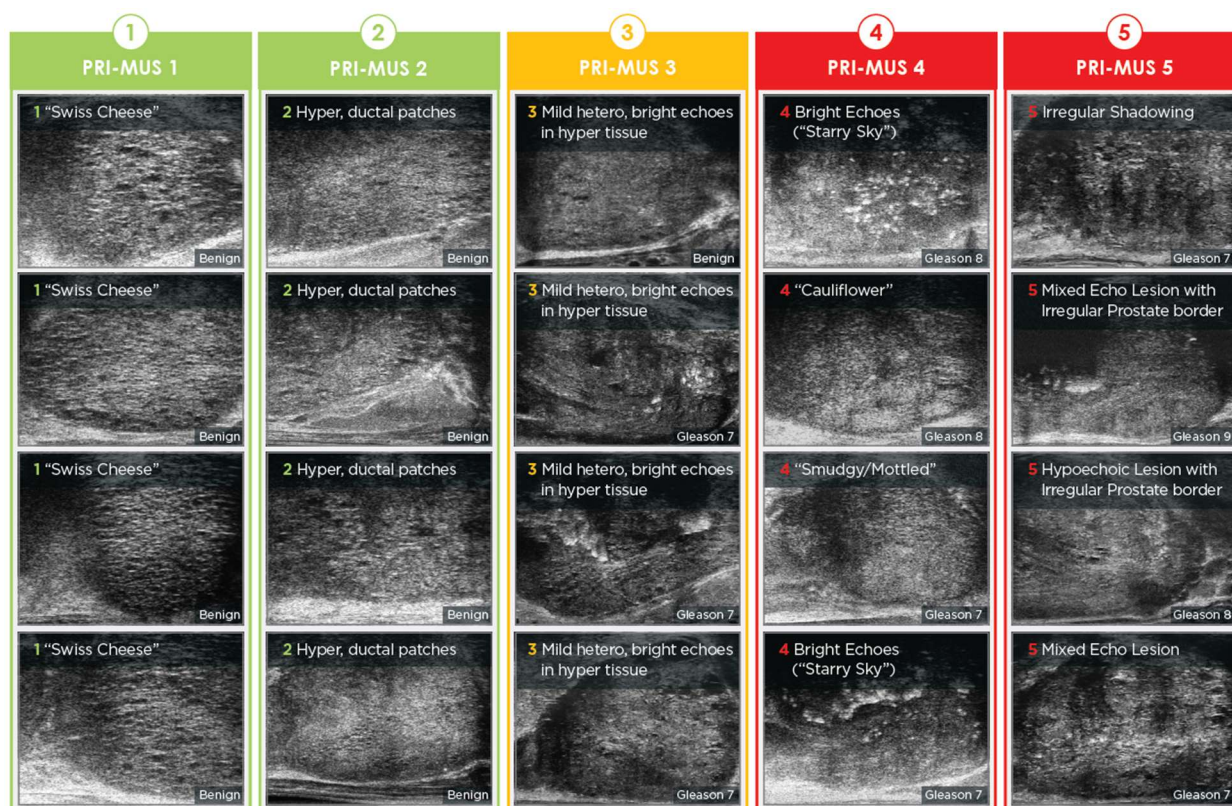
Example images demonstrating the various imaging features of the PRI-MUS protocol. This risk-stratification protocol grades images based on tissue patterns seen in micro-ultrasound from 1 (very low risk for significant cancer) to 5 (very high risk of significant cancer).
